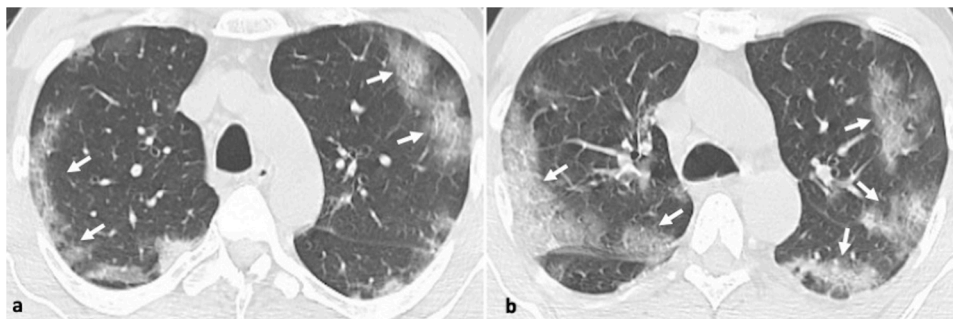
51-year-old male with confirmed Covid-19 pneumonia. 9a, b. Axial CT images show typical CT appearances with bilateral peripheral ground glass opacities (arrows).
